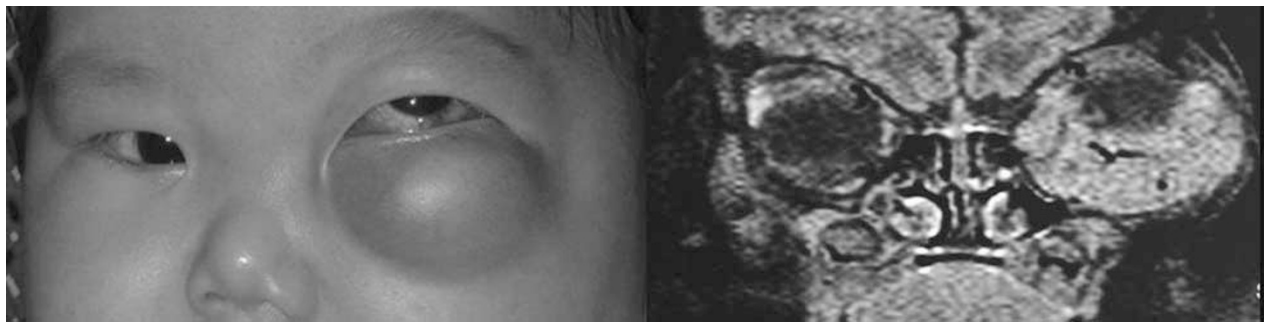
Photo on the left showing a large lower lid swelling causing non-axial proptosis and a coronal MRI scan on the right showing flow voids in the left orbit suggestive of a capillary haemangioma.
